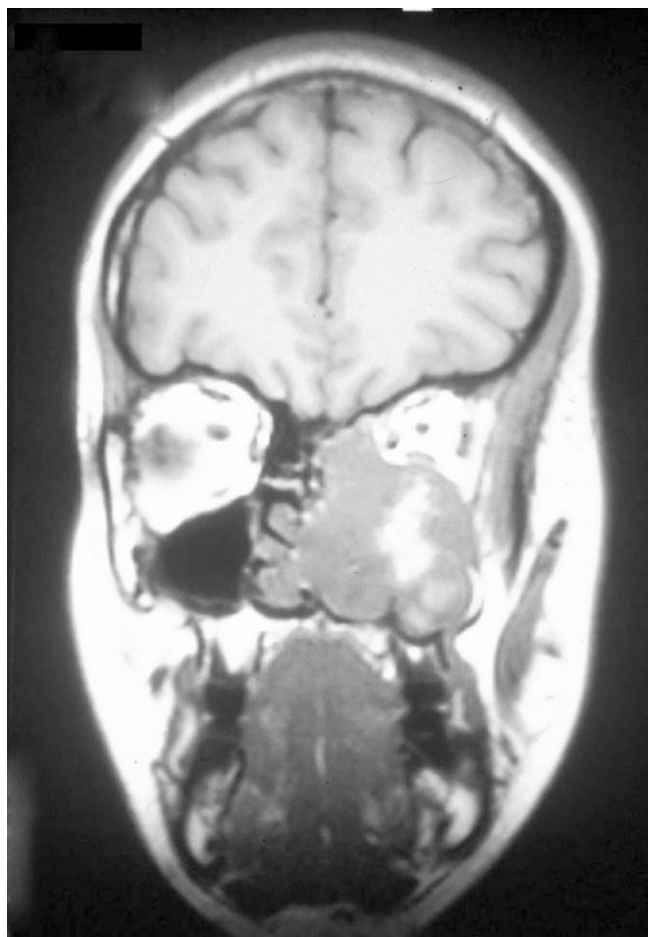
Primitive neuroectodermal tumor: MRI displaying a destructive mass involving the right maxillary sinus, expanding to the orbit and to both sides of the nasal cavity
